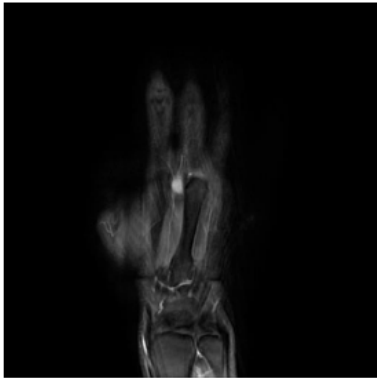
MRI with contrast: superficial subcutaneous well defined mass on the dorsal aspect between 2nd and 3rd MCP joints
